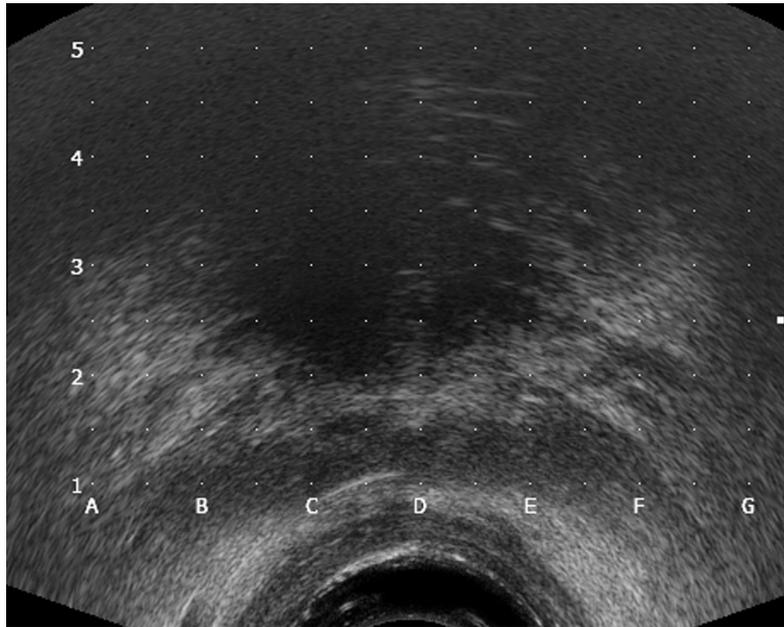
Transaxial transrectal ultrasound image with template positions identified on image showing set up for HDR prostate brachytherapy to include seminal vesicle.
